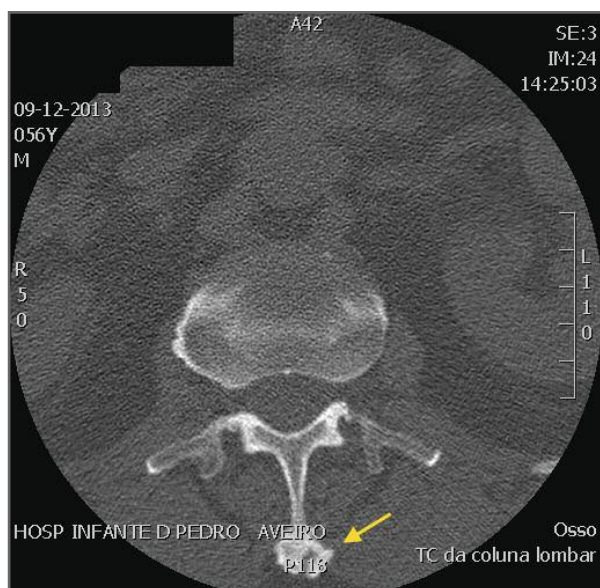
Lumbar CT (axial view) showing enlargement of the spinous process
